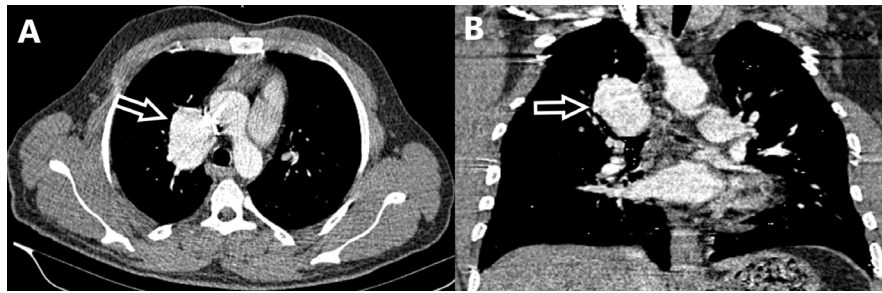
A solitary peripheral pulmonary aneurysm in the upper lobe of the right lung is observed in contrast-enhanced axial (A) and coronal (B) thorax CT in a 32-year-old male patient with idiopathic etiology
